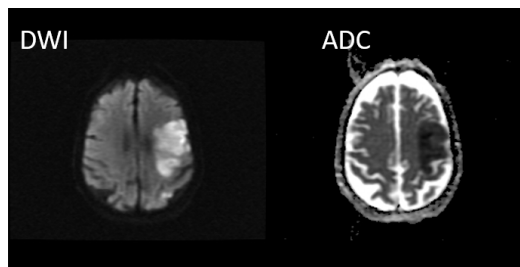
Example of DWI type image and ADC type image. Image taken from [1]
